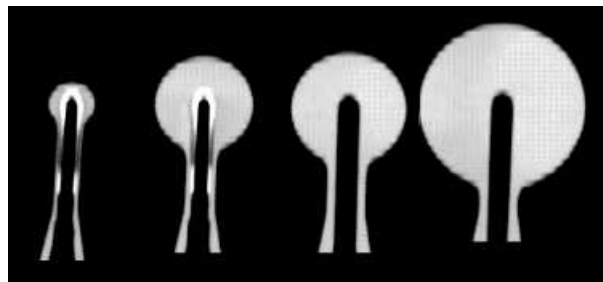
Computed tomography image showing the cross-section of 1.5 cm, 3.0 cm, 3.5 cm and 5.0 cm diameter applicator [Eaton and Duck, 2010].
